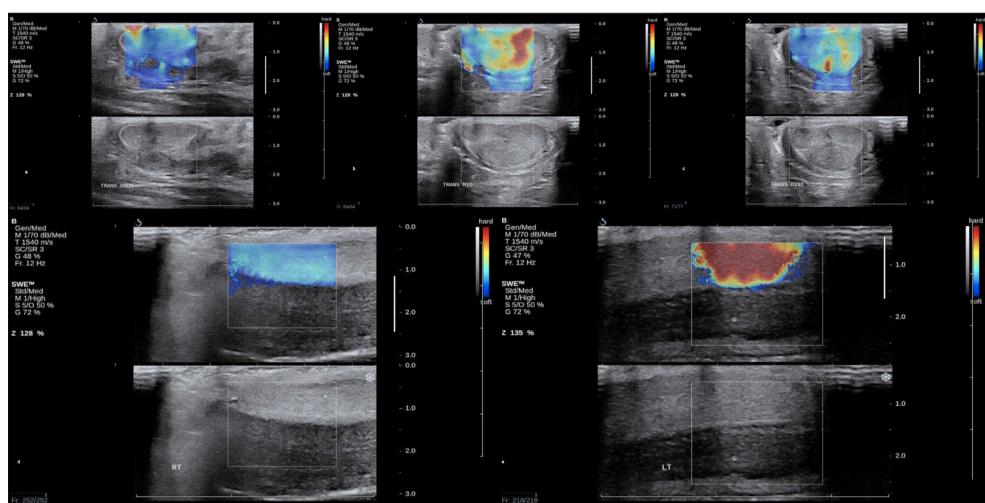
Penile Elastography. Penile ultrasound demonstrating the presence of non-calcified penile plaques in Peyronie's disease through the use of elastography. Penile plaques are identifiable on elastography as areas of increased tissue density, shown in the above figures as red (note right bottom images). These non-calcified plaques are not visible on standard B-mode imaging.
